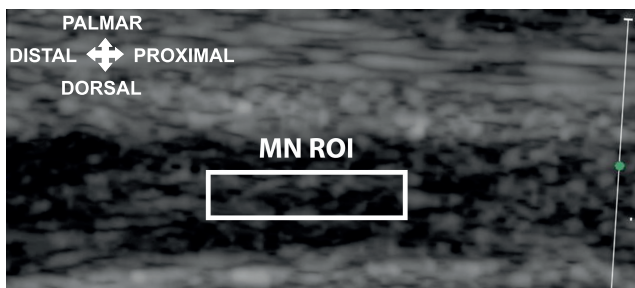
Representative example of a longitudinal plane ultrasound scan of the median nerve (MN) with placement of the region of interest (ROI).
